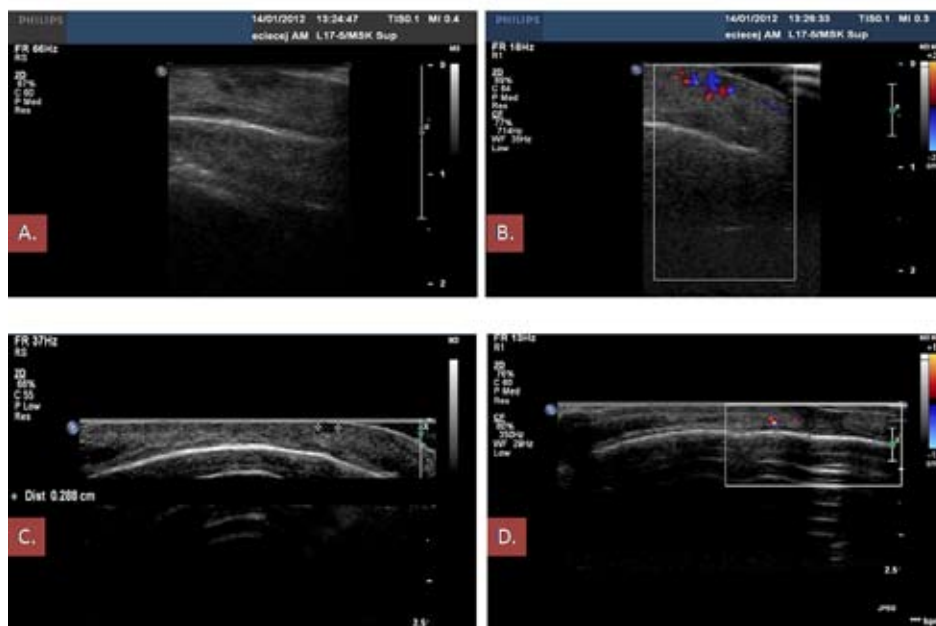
Case 2. US examinations. A. The lesion within the dermis of non-homogeneously decreased echogenicity crossing the dermoepidermal junction, poorly delimited and irregular. B. Color Doppler scan showing numerous vascular flow signals within the lesion. C. Recurrence, 2.8 mm in size. D. Color Doppler scan – vascular flow signals within the dermis around the focus.
